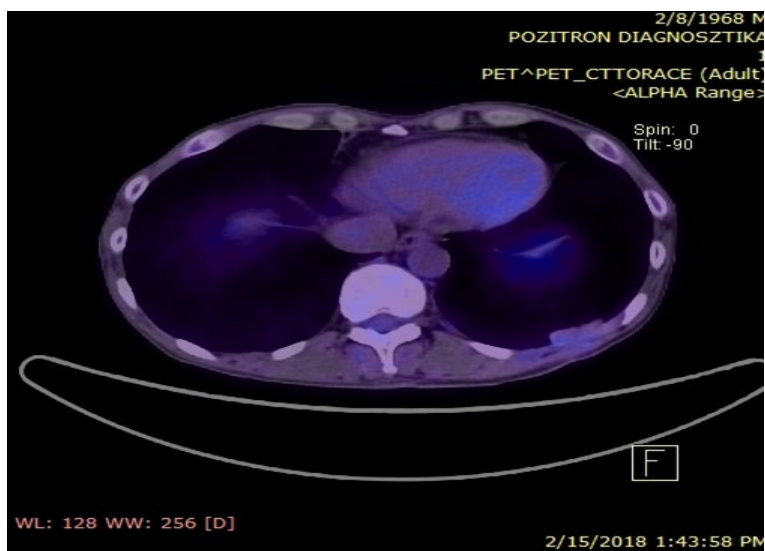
PET-CT (15.02.2018): Complete Response
